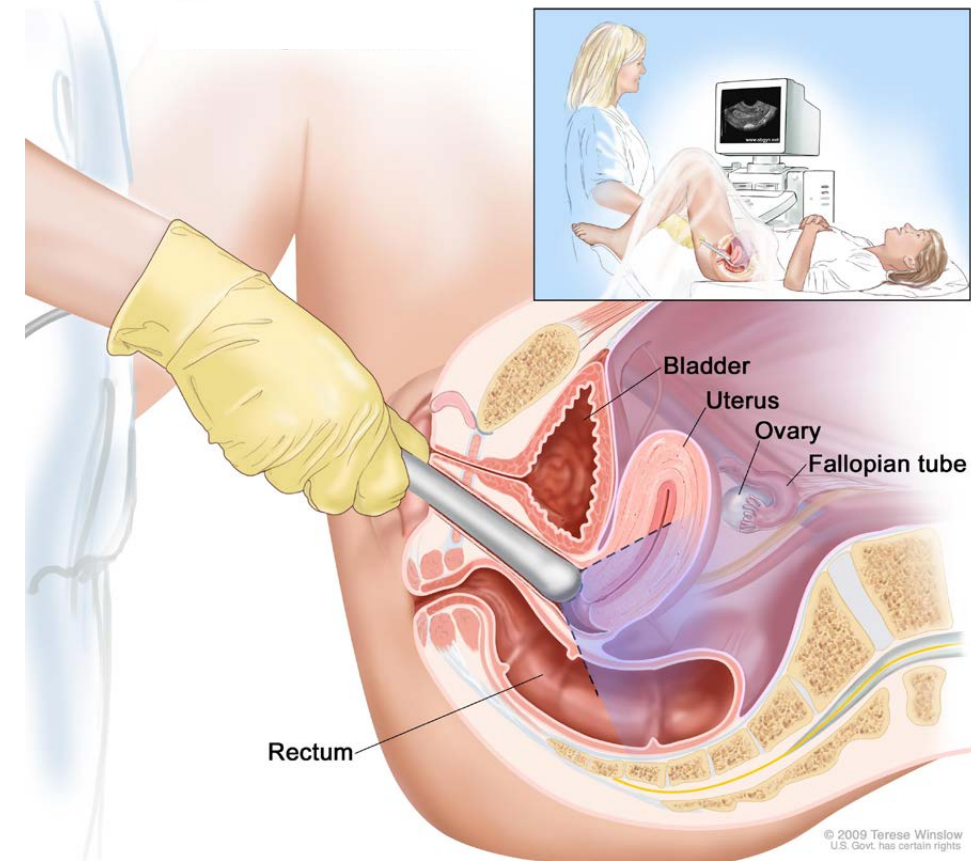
Transvaginal ultrasound
